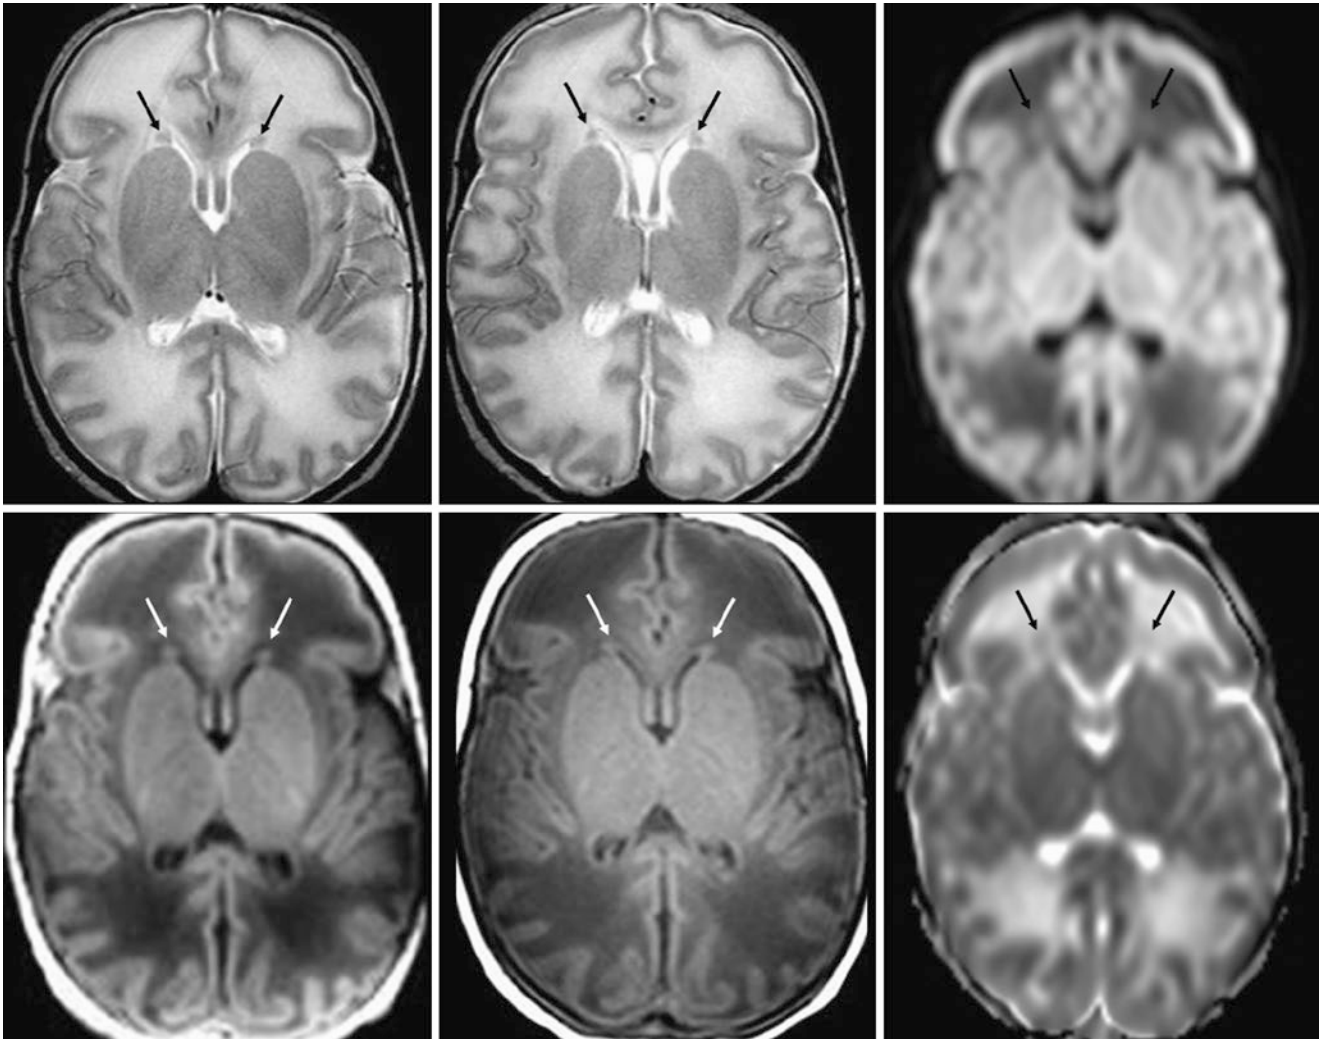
A 36-week-old premature infant. *Top row:* Residual germinal matrix (RGM) (*thin arrows*) is adjacent to the lateral ventricles' frontal horns on 3T axial SE T2WI (*left and middle*) and DWI (*right*).
